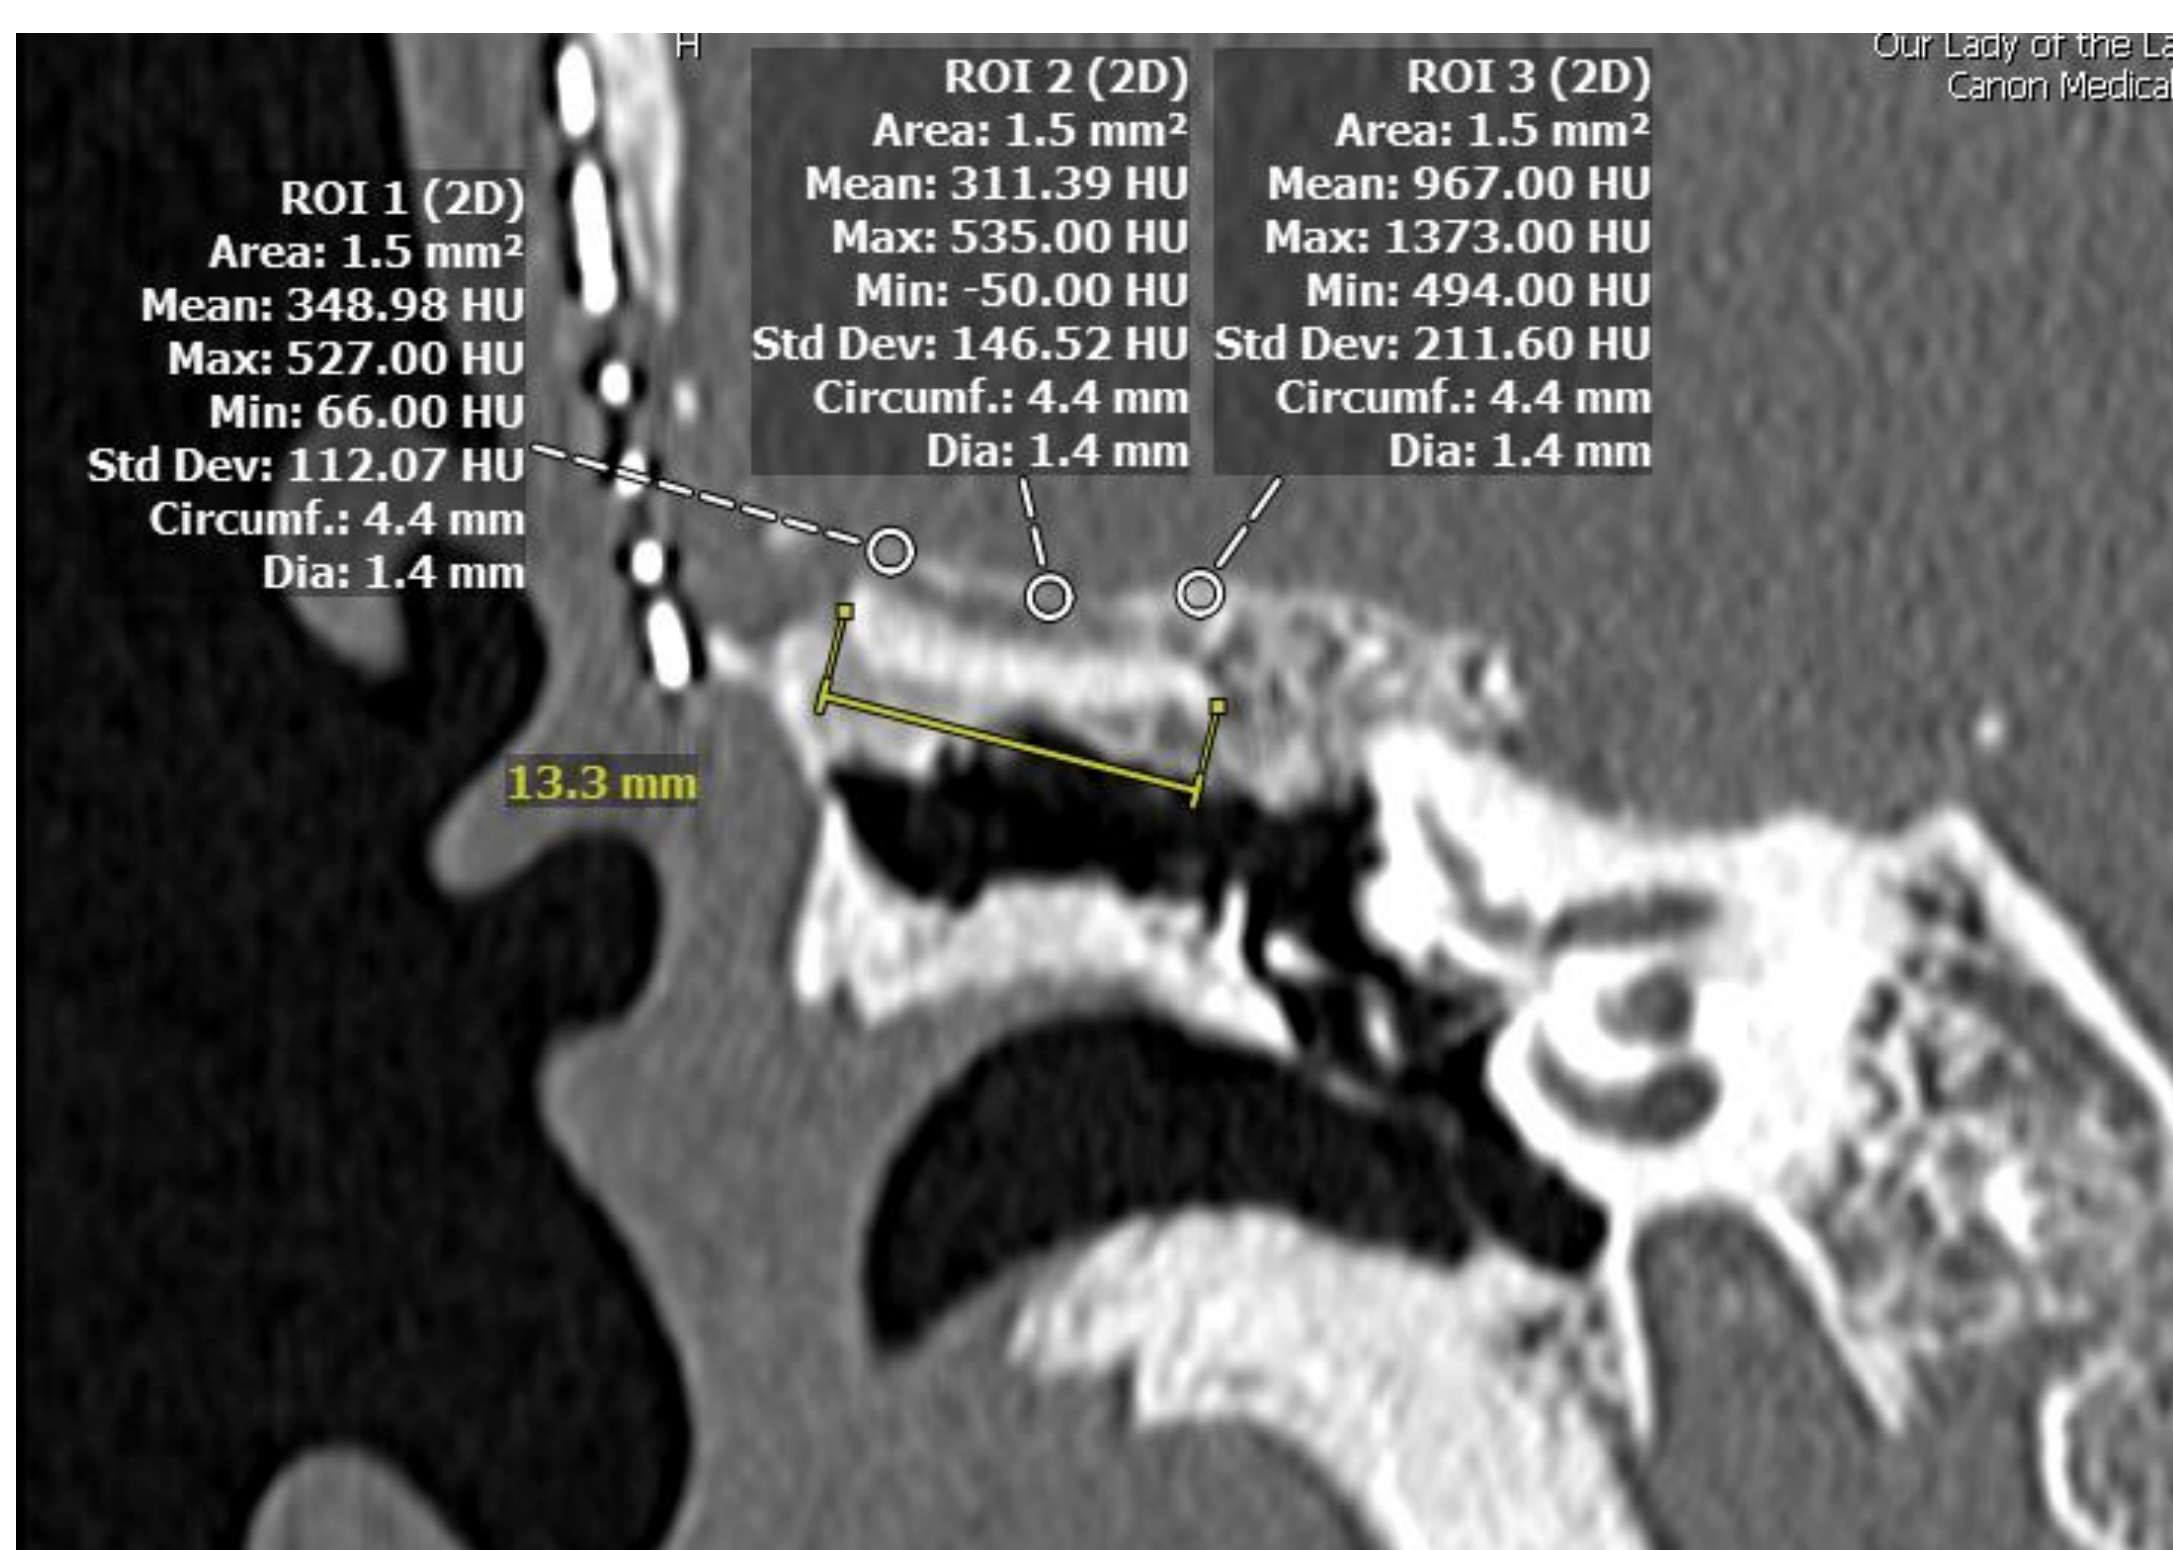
Representative CT temporal bone in coronal plane showing radiodensity measurements at three distinct locations (medial edge, middle, lateral edge) along the superior layer of the graft.
